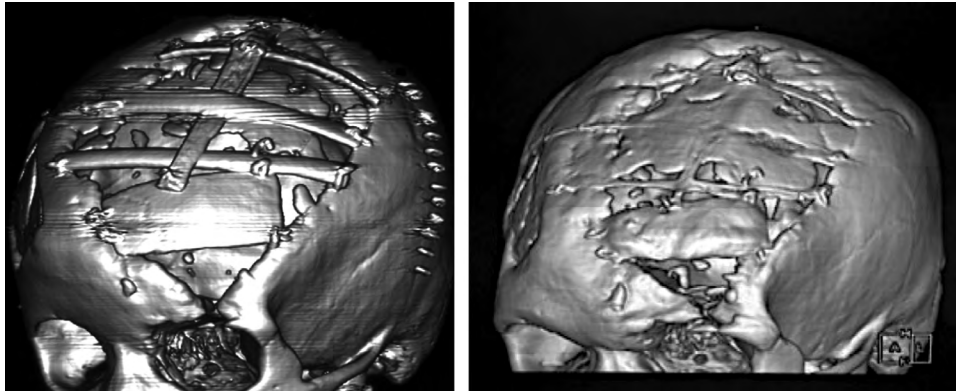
Catcher's mask cranioplasty in a 6-year-old boy. A, The CT image 6 days after the cranioplasty. (Retrieved with permission from Ichiro T, Masataka A. Catcher's mask cranioplasty for extensive cranial defects in children with an open head trauma: a novel application of partial cranioplasty. *Childs Nerv Syst* 2008;24:927–932). B, The CT image 11 years after the cranioplasty at the age of 17 years.
